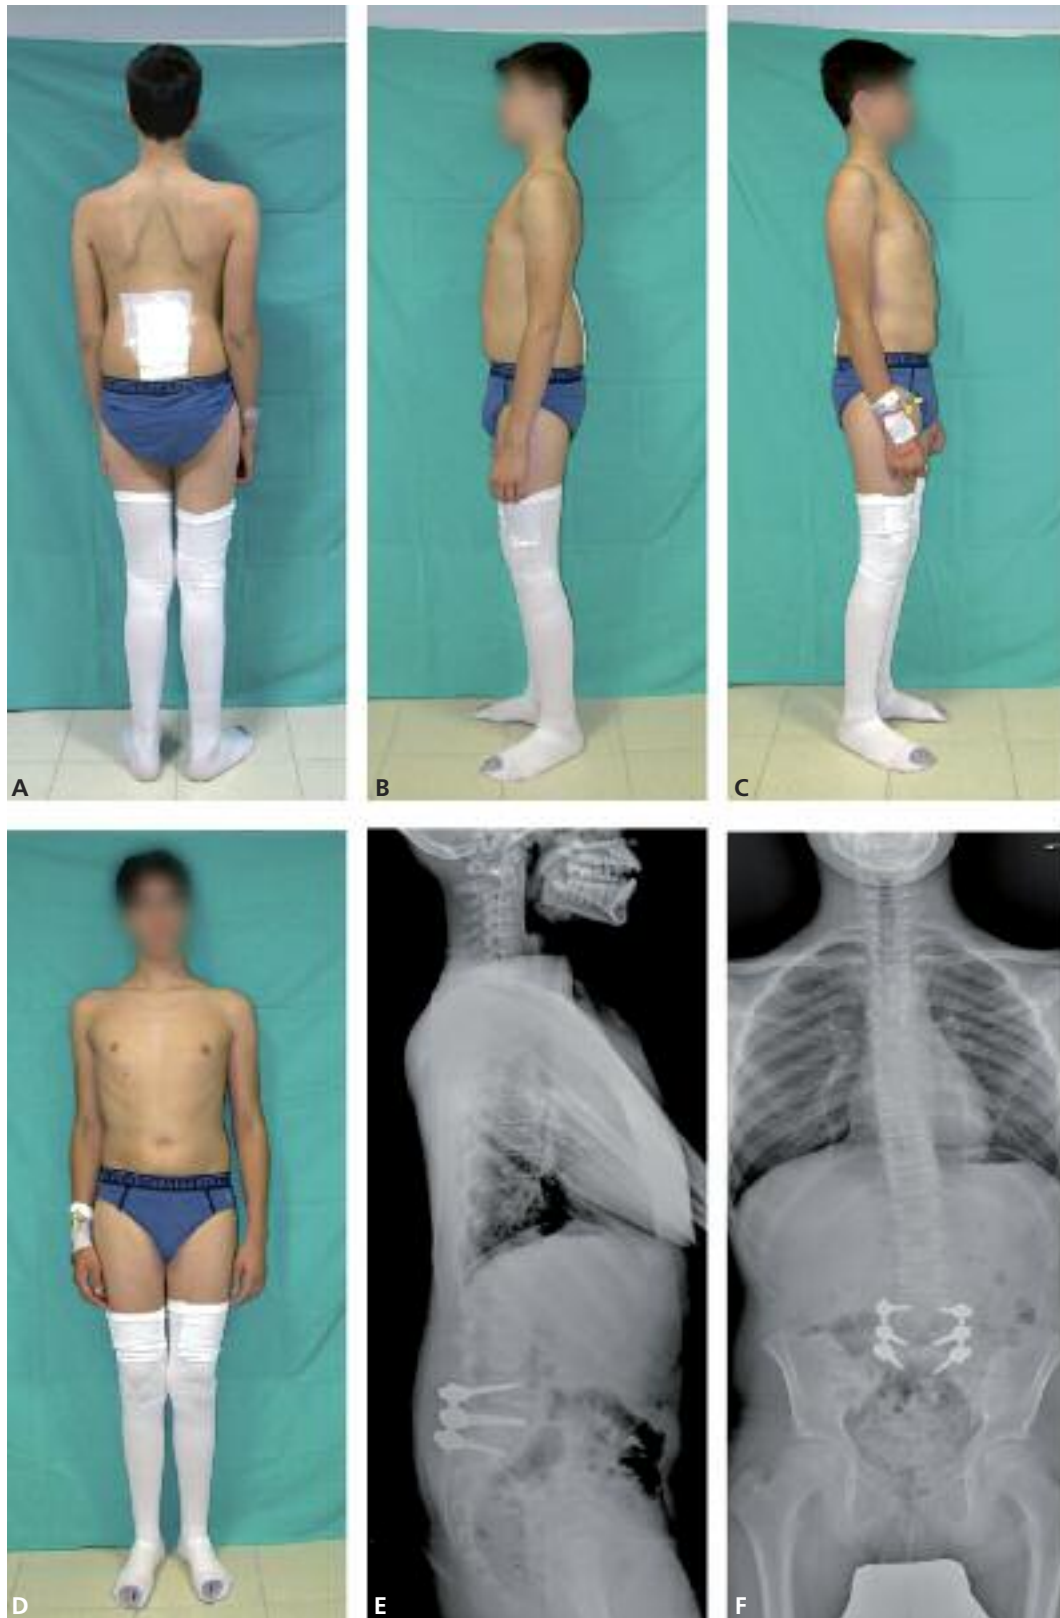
Postoperative pictures (*A-D*) and Postoperative lateral and anteroposterior X-ray (*E-F*), showing a satisfactory reduction of the listhesis. Frontal and sagittal balance were partially restored.
